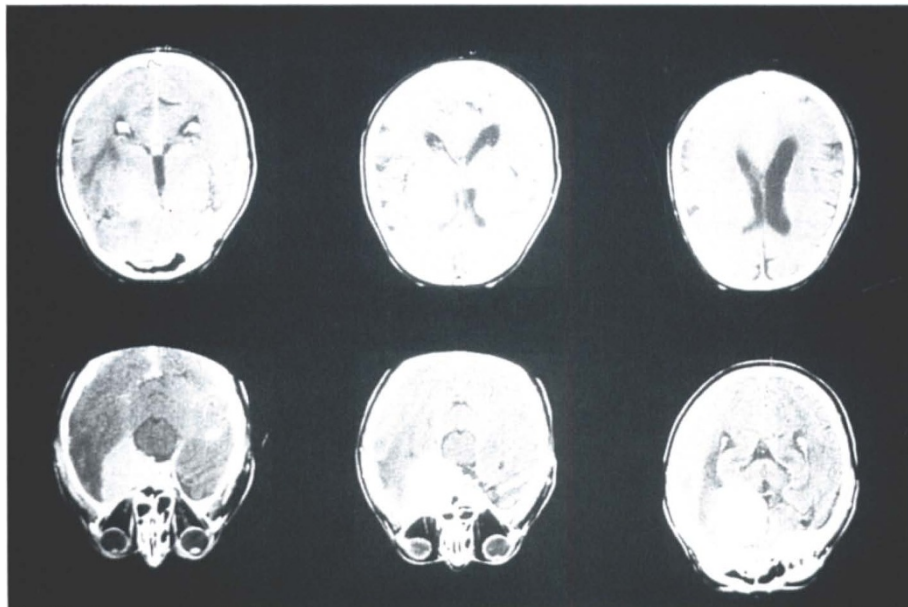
CT scan of the brain and orbits, showing a large contrast-enhanced sphenoidal ridge meningioma on the right.
